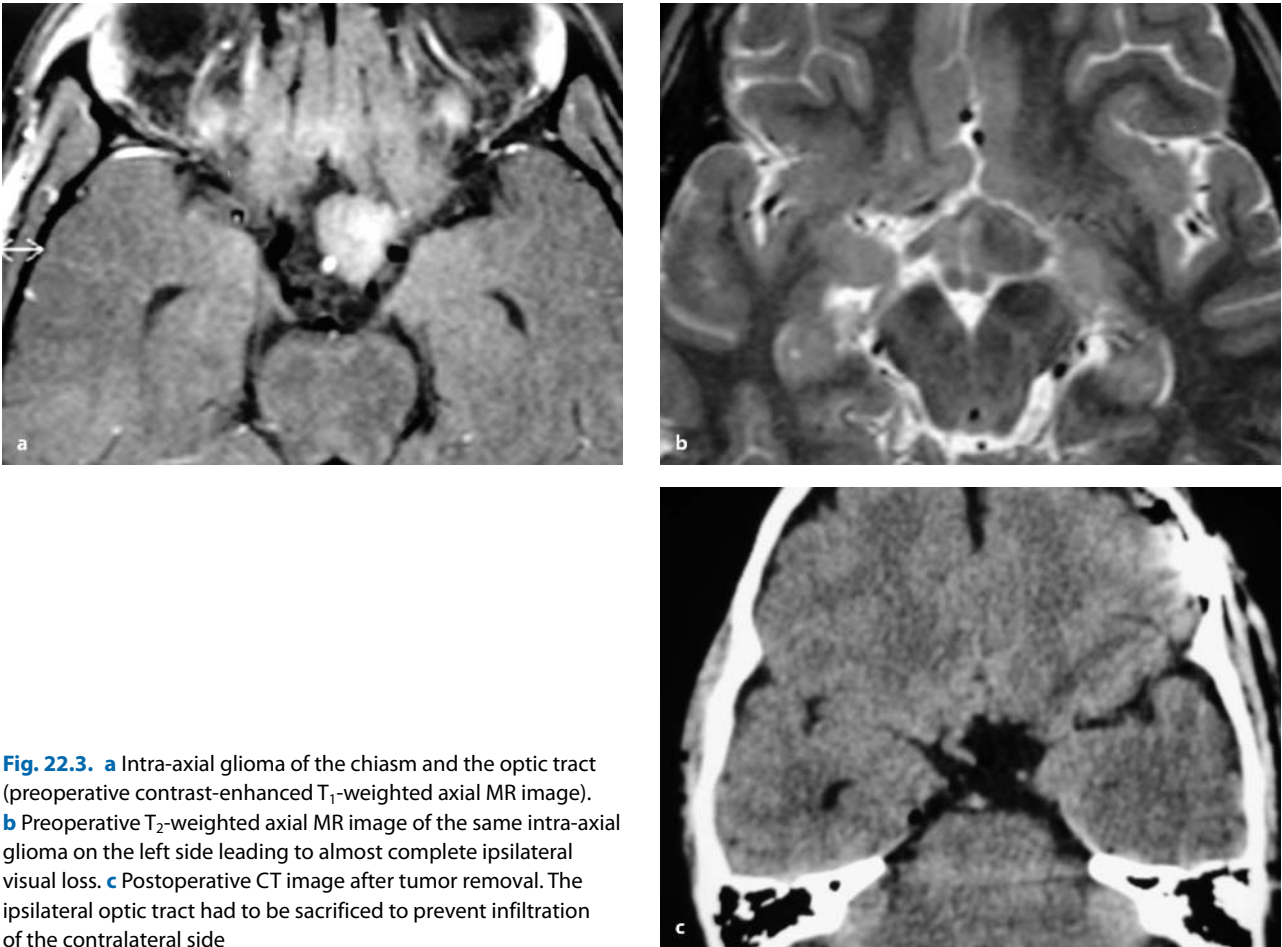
a Intra-axial glioma of the chiasm and the optic tract (preoperative contrast-enhanced T₁-weighted axial MR image). b Preoperative T₂-weighted axial MR image of the same intra-axial glioma on the left side leading to almost complete ipsilateral visual loss. c Postoperative CT image after tumor removal. The ipsilateral optic tract had to be sacrificed to prevent infiltration of the contralateral side
